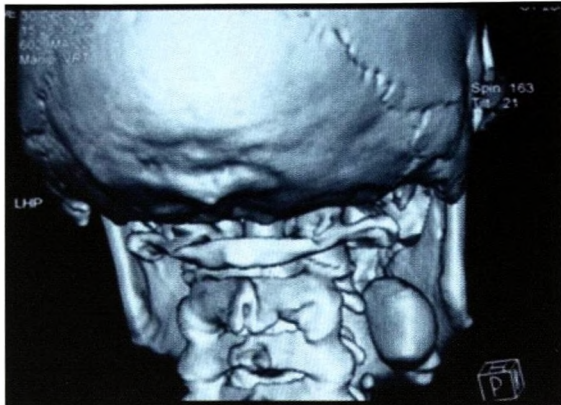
3D CT image of the sialolith in the submandibular region.
